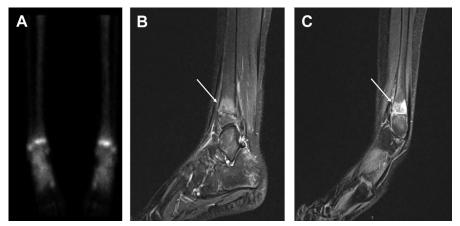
(*A*) Normal bone scintigraphy of a child. (*B*) Abnormal STIR signal (*arrow*) on MRI within left distal tibia of the same child. (*C*) Abnormal STIR signal (*arrow*) on MRI within right distal fibula of the same child.
